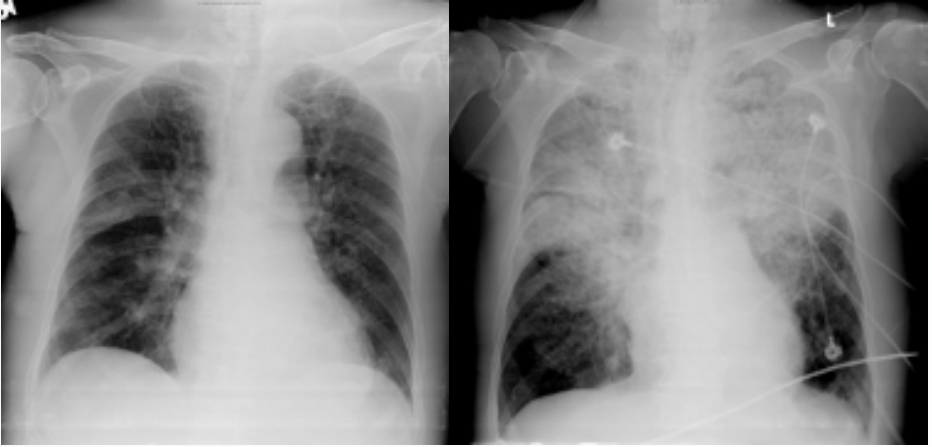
Chest radiograph obtained on the first day (left) and the fourth day (right) of admission found significant patchy infiltration of bilateral lung compared to baseline.
